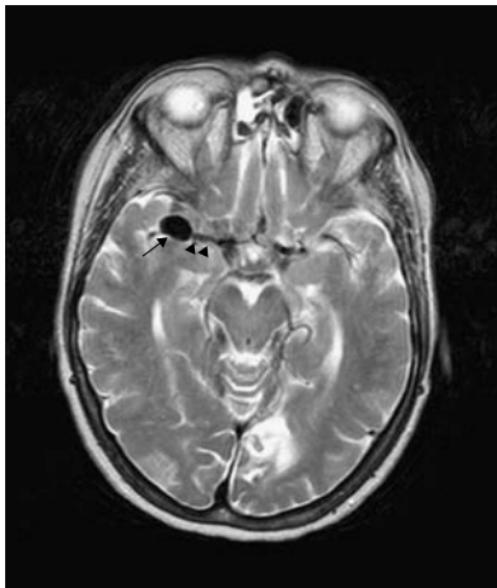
Right middle cerebral artery (MCA) aneurysm and acute SAH. (a) Non-enhanced CT; (b) axial T2-weighted; (c) 3-dimensional TOF MRA of the circle of Willis; and (d) MRA maximum intensity projection (MIP) MRI. Extensive acute subarachnoid haemorrhage is shown within the anterior interhemispheric fissure, fourth ventricle, and Sylvian fissures, prominently on the right (white arrow). Communicating hydrocephalus. The distribution is suggestive of a right MCA aneurysm which is shown on subsequent MRI as a rounded signal flow void (black arrow).
